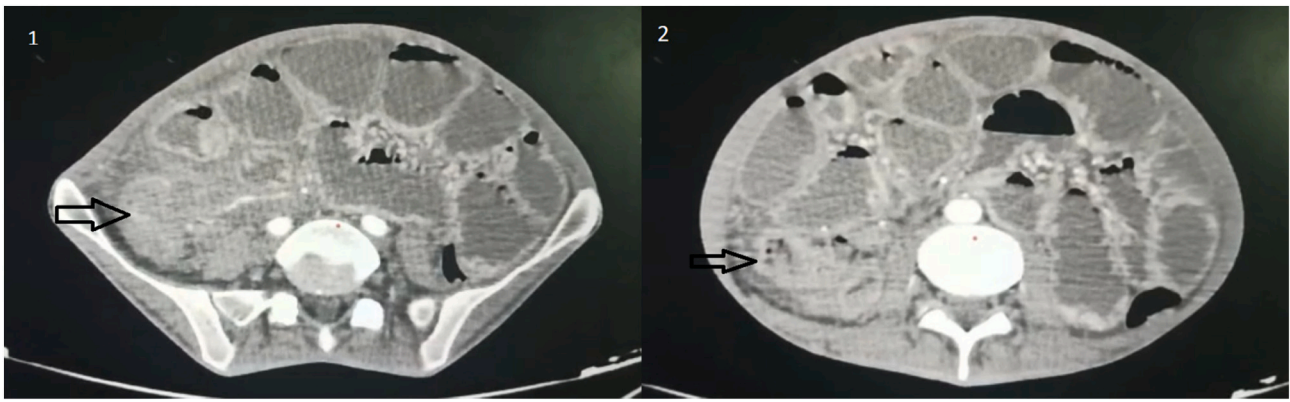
Abdominal CT scan showing an intestinal occlusion upstream a thickening of the Cecum.
